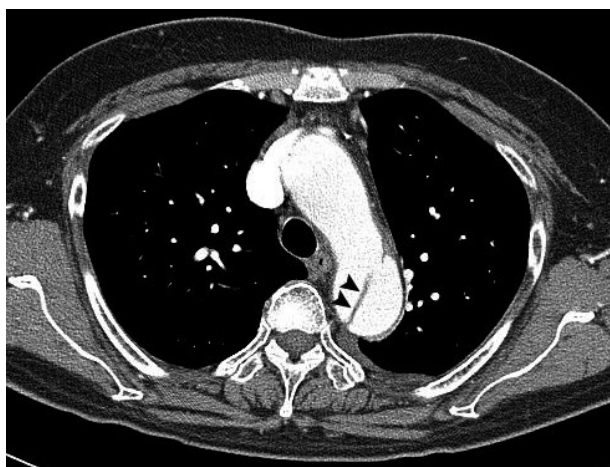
Diagnostic delay in a 66-year-old female patient with Stanford type B dissection. This patient had a history of coronary stent insertion 2 years ago. The patient presented with acute chest pain to the emergency department. Emergent coronary angiography showed no significant stenosis in the coronary arteries. A Stanford type B aortic dissection (arrowheads) is noted on a trans-axial CT image at the level of aortic arch obtained 24 hours after coronary angiography.
